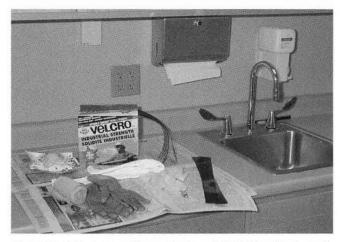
Office set-up for application of Delta-Cast Conformable splint including: one roll of cast material, x-ray strips, padded stockinette, casting gloves, scissors, and velcro.
